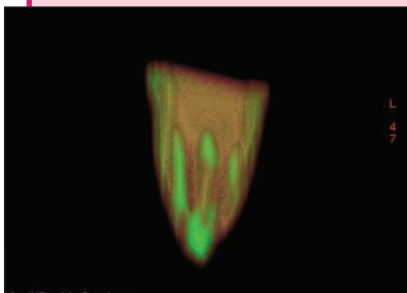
CT image of mesiobuccal and mesiolingual canals after removal of filling material with the Profile .04 rotary system.
